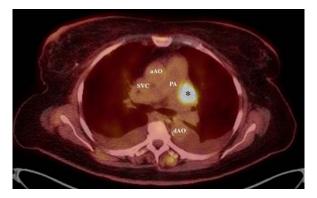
Fused PET-CT demonstrating a single lesion in the territory of lymph node station 5(*). aAO indicates ascending aorta; dAO, descending aorta; PA, pulmonary artery; SVC, superior vena cava.
